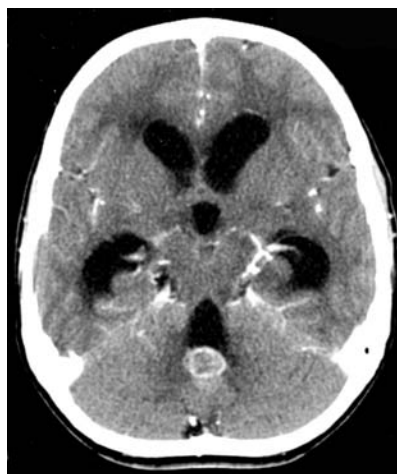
Post contrast CT scan in axial plane showing a tuberculoma adjacent to fourth ventricle with hydrocephalus
